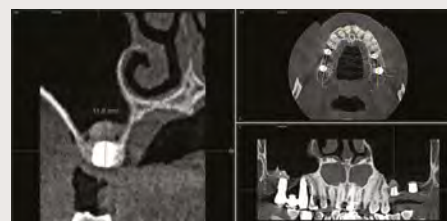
Cone-beam image before loading showing the vertical bone gain achieved in the area
